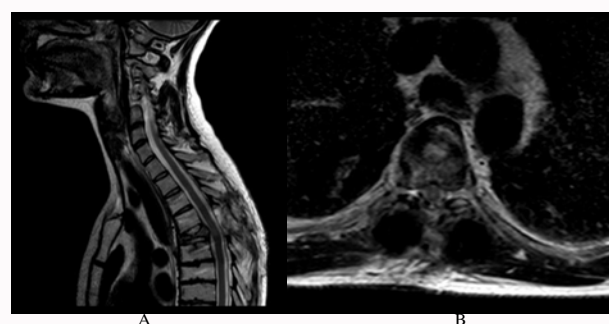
T1 postcontrast MRI sagittal image (A) and post-contrast axial image (B) showing T5 pathologic fracture with less tumor extension into the epidural space at three months from surgical decompression-stabilization and one month after beginning palbociclib plus hormonal therapy.
